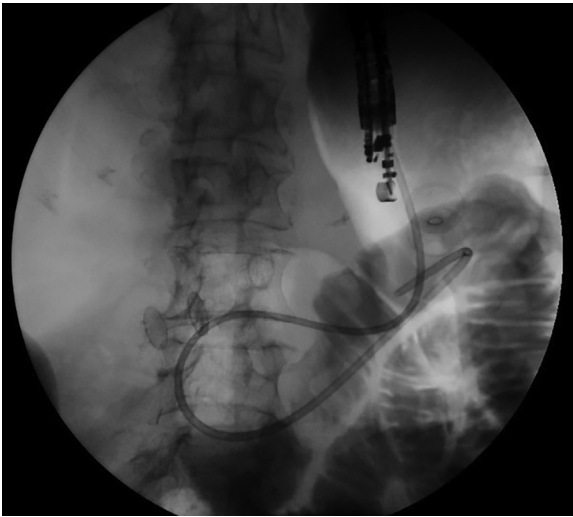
Abdominal radiograph demonstrating successful creation of a gastroenterostomy using a lumen-apposing metal stent.
